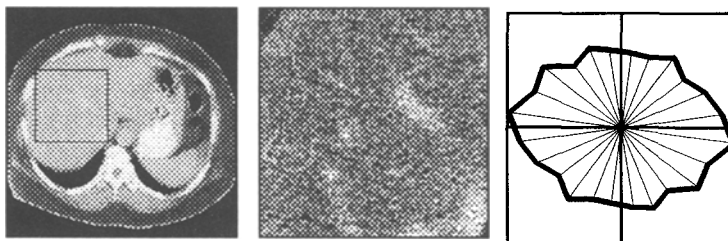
"True" orientational histogram of liver texture (liver CT image, $K_a=1.51$).
